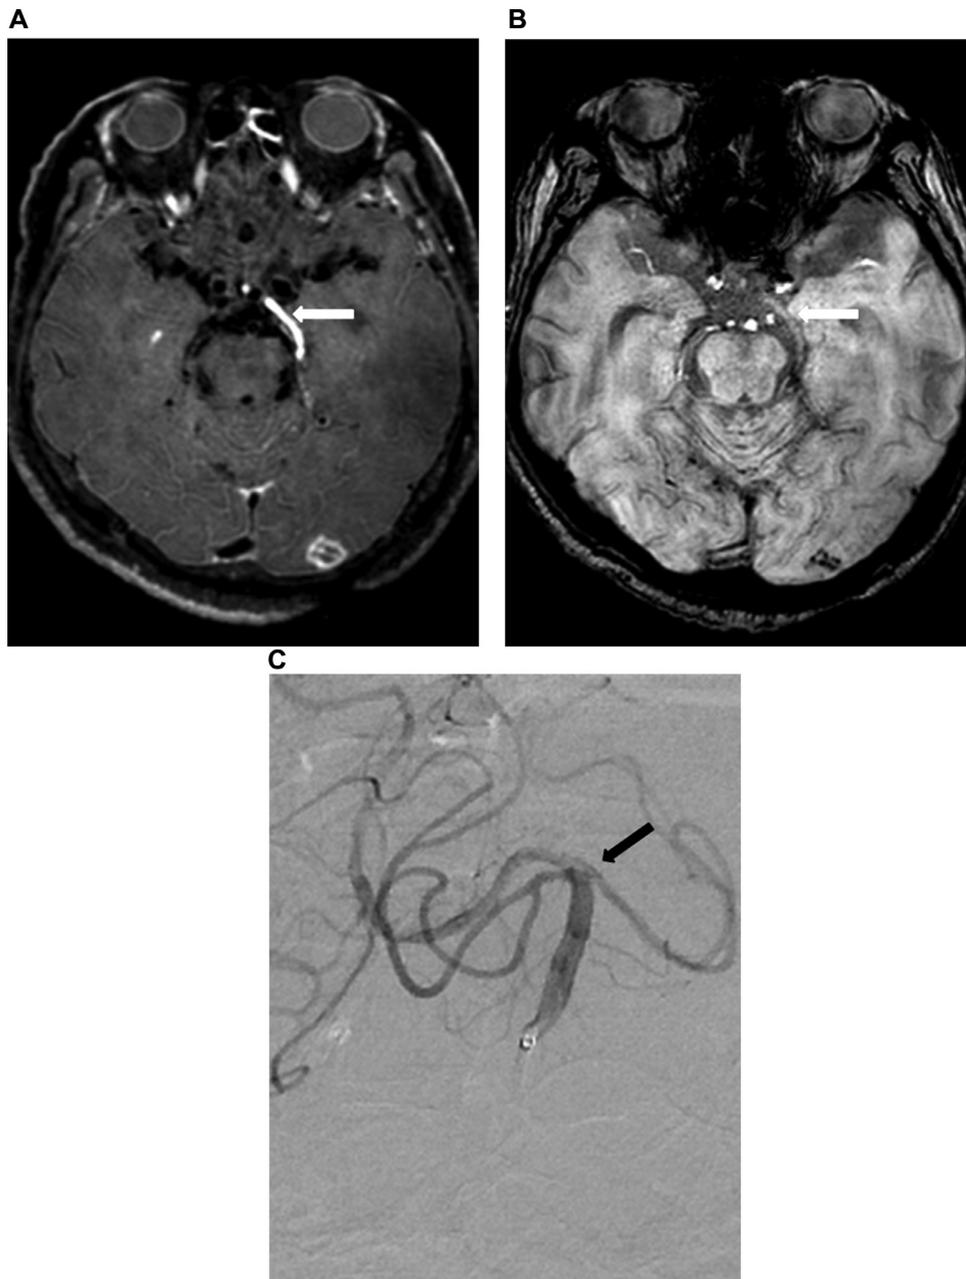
A 69-year-old man with unilateral posterior cerebral artery (PCA) occlusion. A. 3D-BB-ceT1-MRI shows strong enhancement due to contrast stagnation in the left PCA (arrow). Strong enhancement at the in situ thrombus and distal portion of the thrombus may be attributed to contrast stagnation and a lack of suppression due to slow flow in the distal portion of the thrombus on BB-ceT1-MRI. B. SWI shows a negative SVS in the left PCA (arrow). C. Angiography of the basilar artery shows complete occlusion of the left PCA orifice (arrow).
